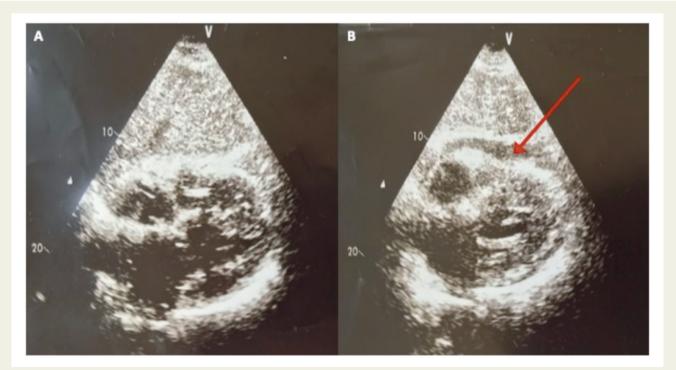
Transthoracic echocardiography in subcostal view obtained before (A) and shortly after (B) application of fluid through the proximal lumen of the tunnelled cuffed haemodialysis catheter, leading to rapid development of a circular pericardial effusion (marked with red arrow).
